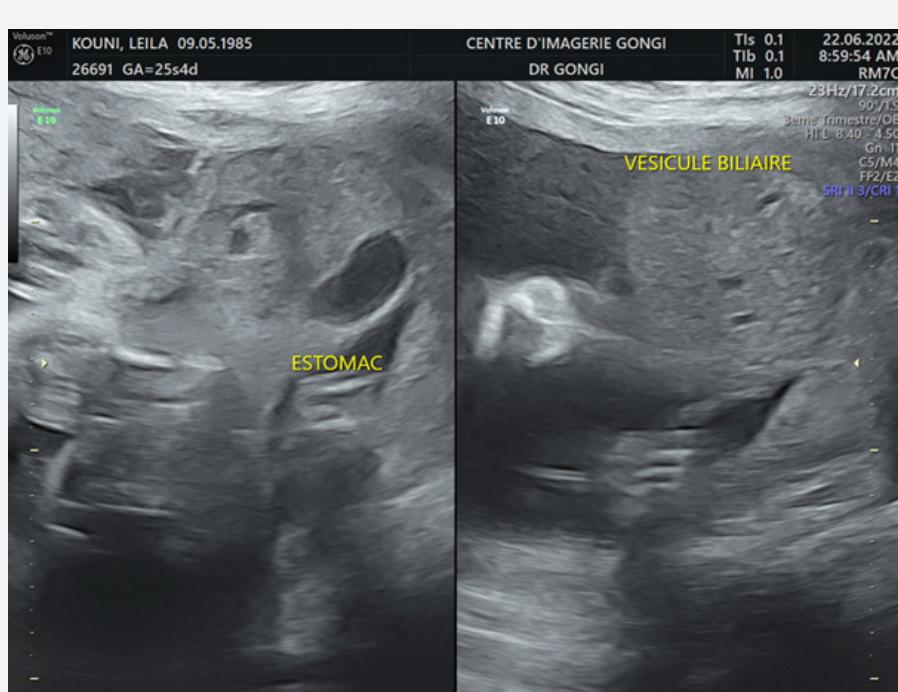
Ultrasound appearance of coelosomy complete, with liver, stomach and intestine bathing in amniotic fluid, in a fetus at 28 SA with short cord syndrome.
